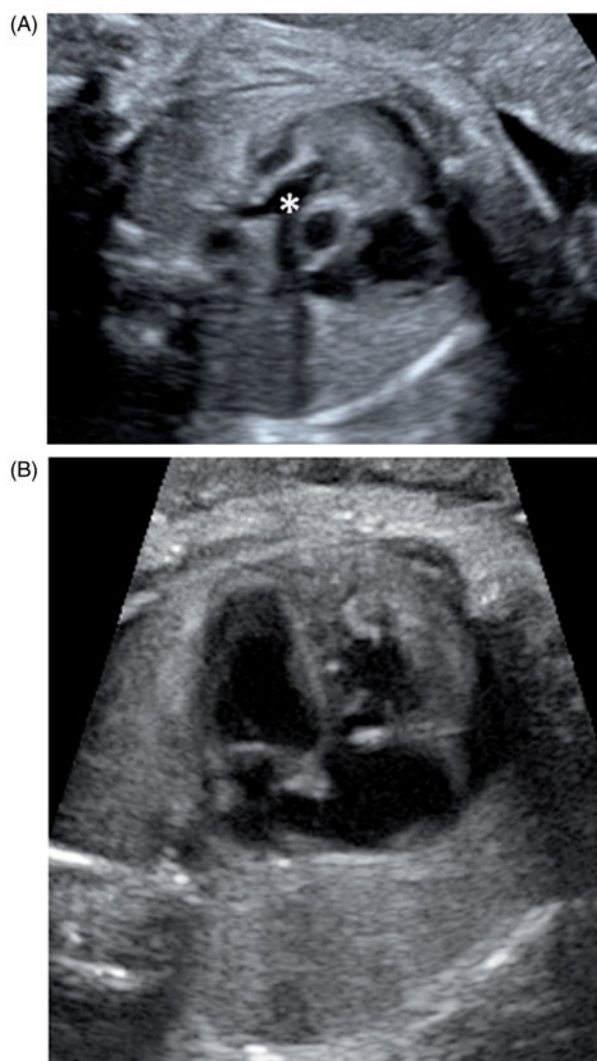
Typical foetal ultrasound presentation of DA closure. (A) Premature DA closure (no 16). No DA demonstrated, adult-type appearance of the pulmonary artery bifurcation (*). (B) Foetal four-chamber view of same foetus; note the severely dilated RA, marked RVH (160% of LV free wall).
